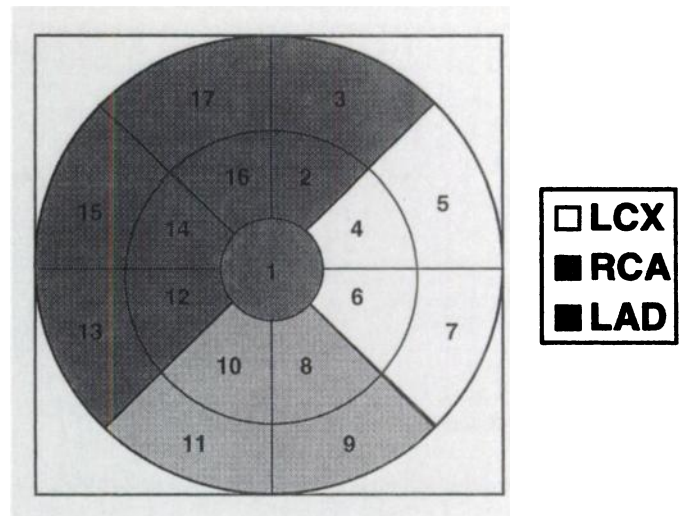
Seventeen-segment SPECT model used for ^{99m}Tc bull's eye SPECT analysis. Segments 1, 2, 3, 12, 13, 14, 15, 16 and 17 were attributed to the LAD territory; segments 4, 5, 6 and 7 to the LCX territory; and segments 8, 9, 10 and 11 to the RCA.
